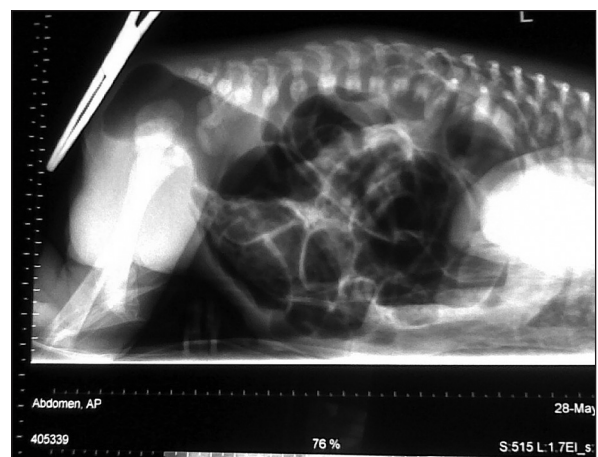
Cross table lateral X-ray showing low anorectal anomaly
